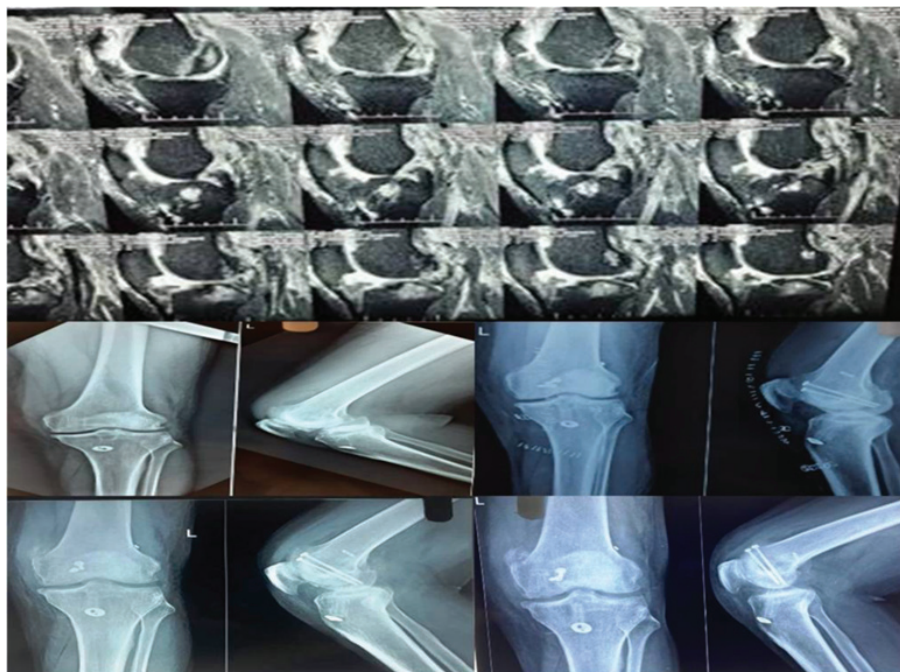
Radiography pre- and post-operative
